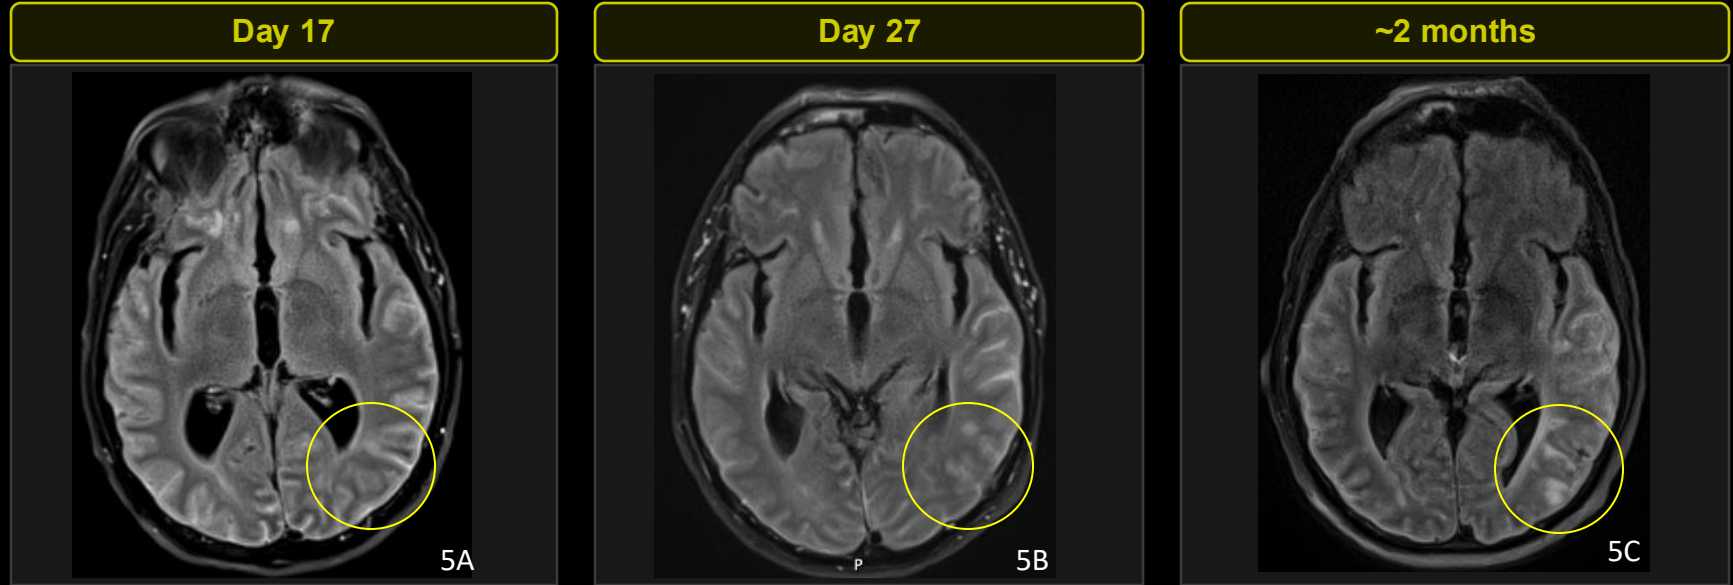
Axial FLAIR at comparable anatomic levels
